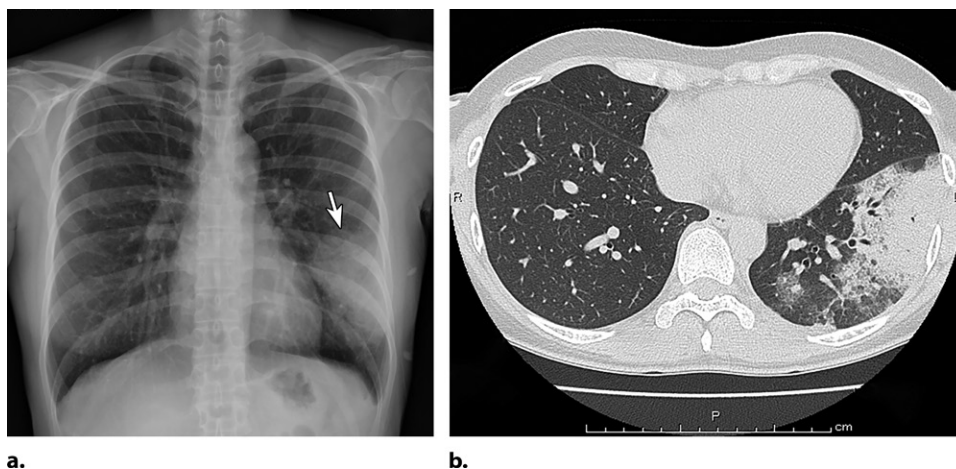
Chlamydia pneumonia in a 38-year-old woman. (a) PA chest radiograph shows a sublobar consolidation in the left lower lobe (arrow) with rounded morphology. (Fig 4a reprinted, with permission, from reference 100.) (b) Axial chest CT image (lung window) shows peripheral consolidation and ground-glass opacities characteristic of lobar pneumonia. No tree-in-bud micronodules or bronchial mucoid impaction are depicted. (Fig 4b courtesy of Takeshi Johkoh, MD, PhD, Kinki Central Hospital of Mutual Aid Association of Public Teachers, Hyogo, Japan.)
